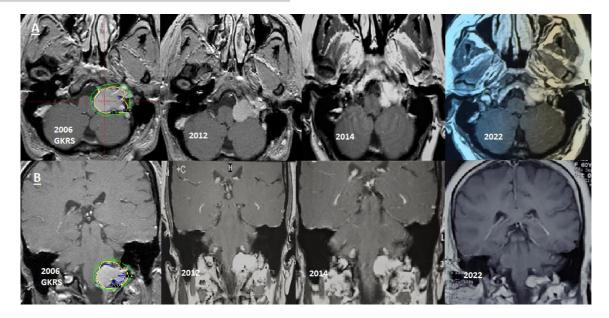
Serial (A) Axial and (B) Coronal contrast MRI brain outcomes. These findings support the hypothesis described by isodose line. Follow-up images in 2012, 2014, and 2022 showed a 25, 36, 37] gradual decrease in treated tumor size starting in 2014 and became Wakefield DV et al. [2], and Dobberpuhl et al. [3], emphasized that more evident in June 2022.
